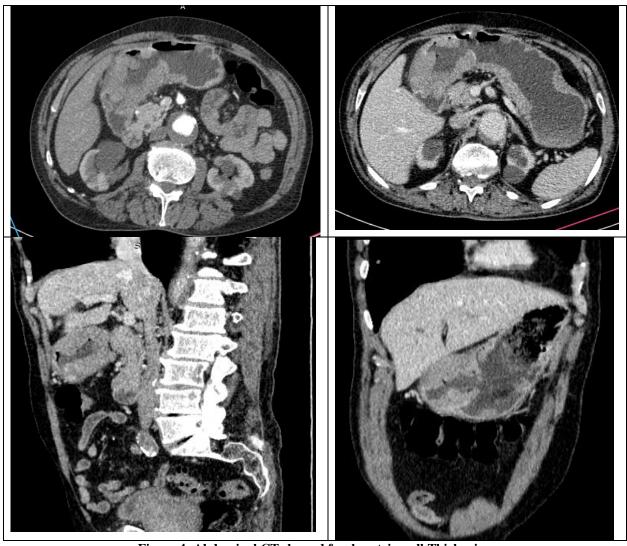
Abdominal CT showed focal gastric wall Thickening
